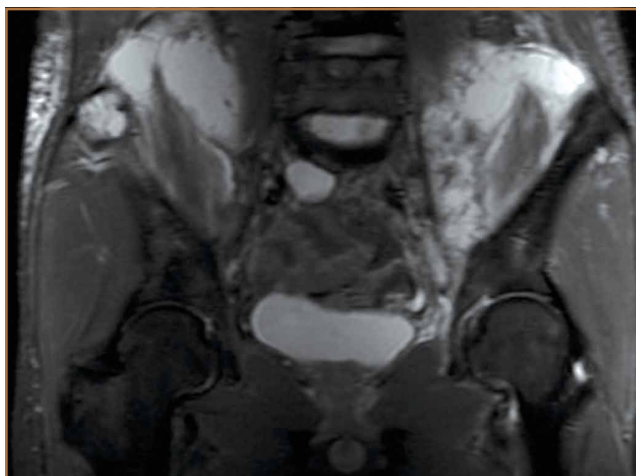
T₂-weighted coronal magnetic resonance imaging shows large granuloma mass extending deep into pelvis, involving psoas and iliacus muscles, and communicating with left flank wound.
